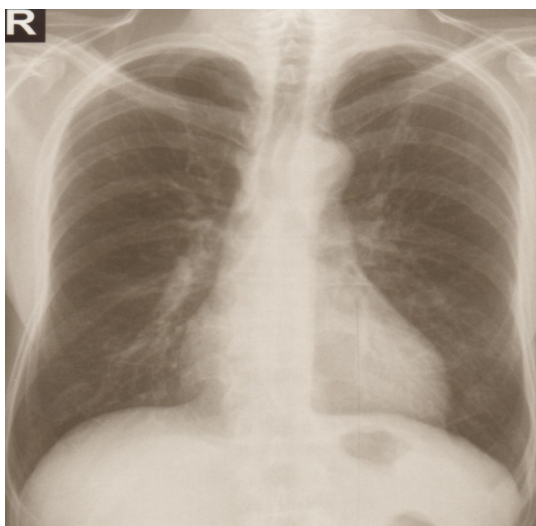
Chest X-ray. COPD. Male age 57
